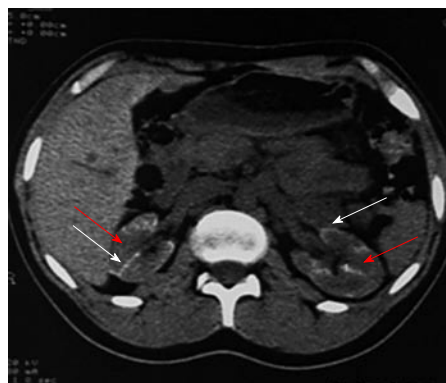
Non contrast computed tomography showing bilateral cortical calcification in a patient with renal cortical necrosis 72 d after acute pancreatitis. Non contrast computed tomography scan of abdomen at the level of renal hila showing linear hyperattenuation along the renal cortical rim (white arrow) with hypoattenuating medulla (red arrow) in bilateral kidney.
